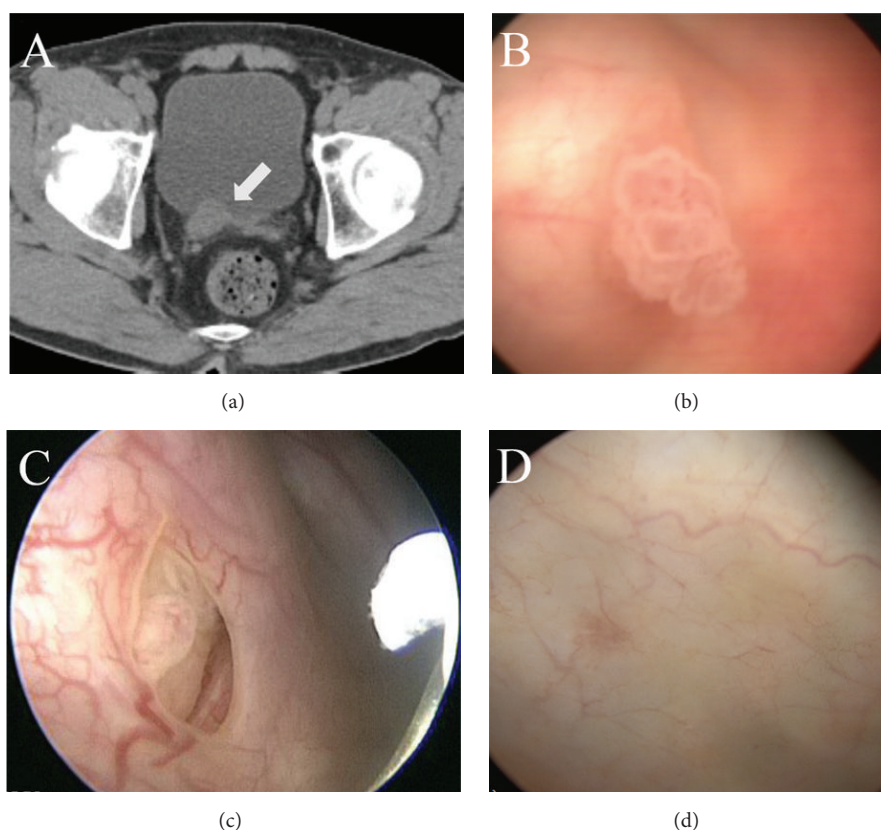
From the upper left, CT scans (a) showed the papillary urothelial carcinoma at the distal right ureter and initial cystoscopy (b) found another mass in the urinary bladder (May 2015). After treating solely with the Korean Medicine treatment, follow-up cystoscopy (c and d) in June and August 2015, respectively, demonstrated its complete remission.
